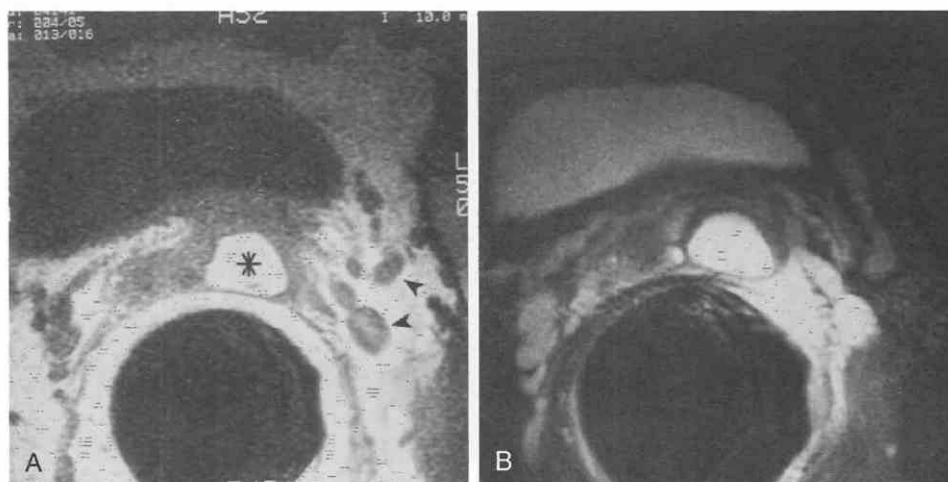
MRI evaluation of ejaculatory dysfunction. *A*, Axial T1-weighted, spin-echo, endorectal coil image shows high-signal-intensity cystic mass in the left seminal vesicle (*asterisk*). Numerous periprostatic veins descend on the left (*arrowheads*), but the seminal vesicle on the left is atrophic. *B*, T2-weighted, fast spin-echo image shows the cystic nature of the mass and again shows absence of the seminal vesicle on the left. The right seminal vesicle is normal and better demonstrated on other images. These findings are typical of a wolffian duct cyst with seminal vesicle aplasia, which was confirmed pathologically.
